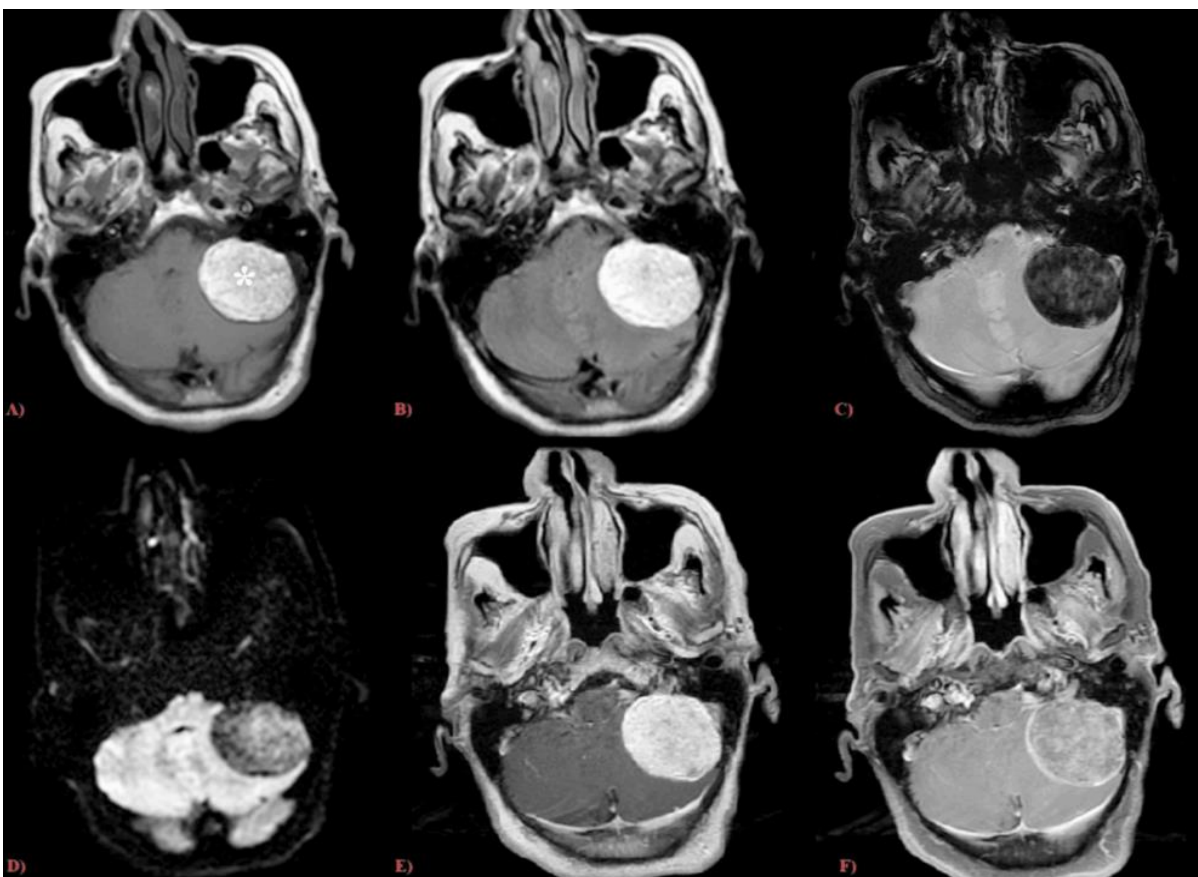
MRI scans in axial weighted shows the extra axial process presenting lipomatous characteristics(asterisk) : hyperintense in T1 (A) and T2 (B), hypointense T1 fat saturation (Fat Sat) WI (C), with no restricted Diffusion (D) , presented a discreet contrast uptake T1 Fat Sat WI (E and F)
